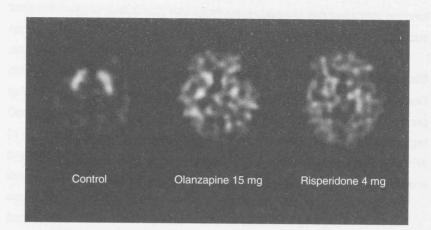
<sup>123</sup>I-IBZM SPECT images of a healthy control and two schizophrenic patients treated with olanzapine (15 mg) and risperidone (4 mg). Transverse slices from the brain at the level of the striatum. The images of the patients clearly show much lower striatal binding of <sup>123</sup>I-IBZM than in the control subject. Levels of SPECT activity are colour encoded from low (black) to high (white). Colour version on the inside of the cover.
